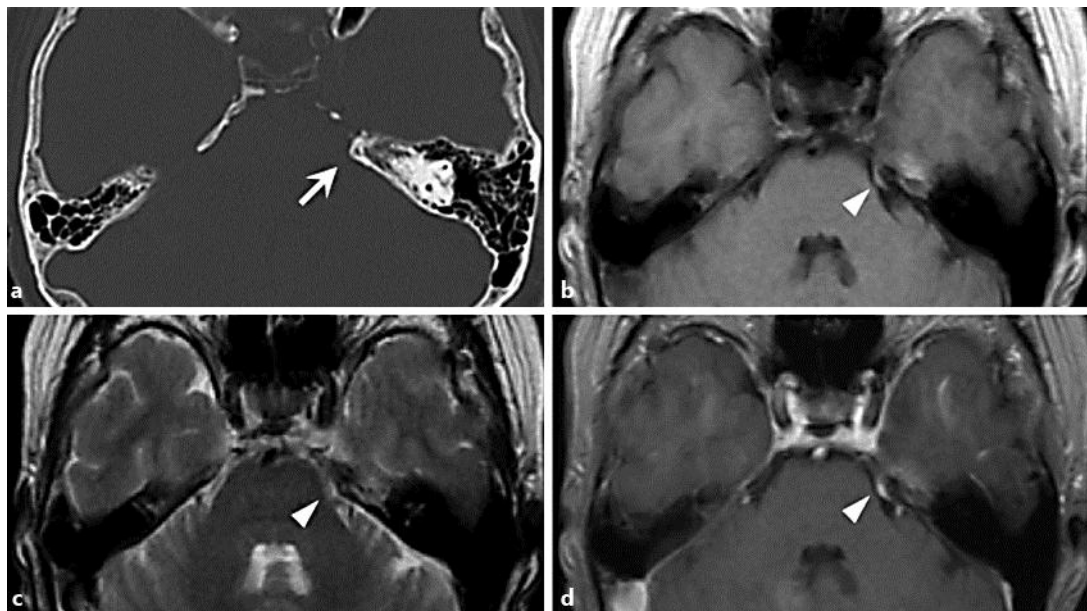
a Preoperative bone-window CT showing the suprameatal tubercle with hyperostosis on the left side (arrow). b T1-weighted image showing an isointense lesion (arrowhead) covering the bony bulge. c T2-weighted image showing the hyperintense lesion (arrowhead). d Gadolinium-enhanced T1-weighted image showing a well-enhanced lesion (arrowhead) covering the bony bulge.
